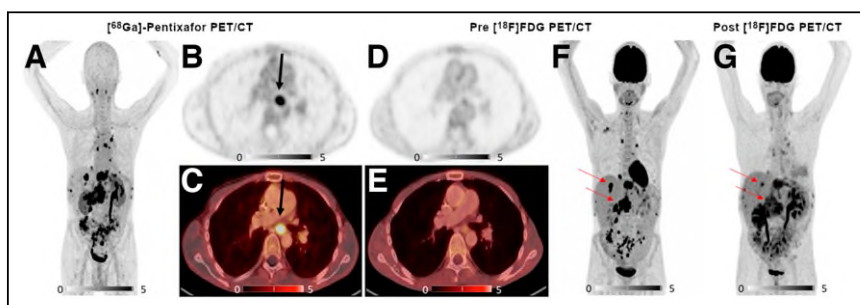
Pre- and posttherapeutic PET/CT scans with [^{68}Ga]pentixafor and [^{18}F]FDG for patient 7. Shown are pretherapeutic coronal (A) and axial (B and C) slices of PET/CT scan with [^{68}Ga]pentixafor and corresponding slices using [^{18}F]FDG (D–F). All metastatic lesions (lymph node, hepatic, and peritoneal implants) demonstrated intensive [^{68}Ga]pentixafor uptake with corresponding [^{18}F]FDG accumulation (F), except for 1 lymph node metastasis in mediastinum (B and C, black arrows). Posttherapeutic [^{18}F]FDG PET/CT shows significantly decreased metabolism of tumor lesions after [^{90}Y]pentixafor therapy (G, red arrows).
